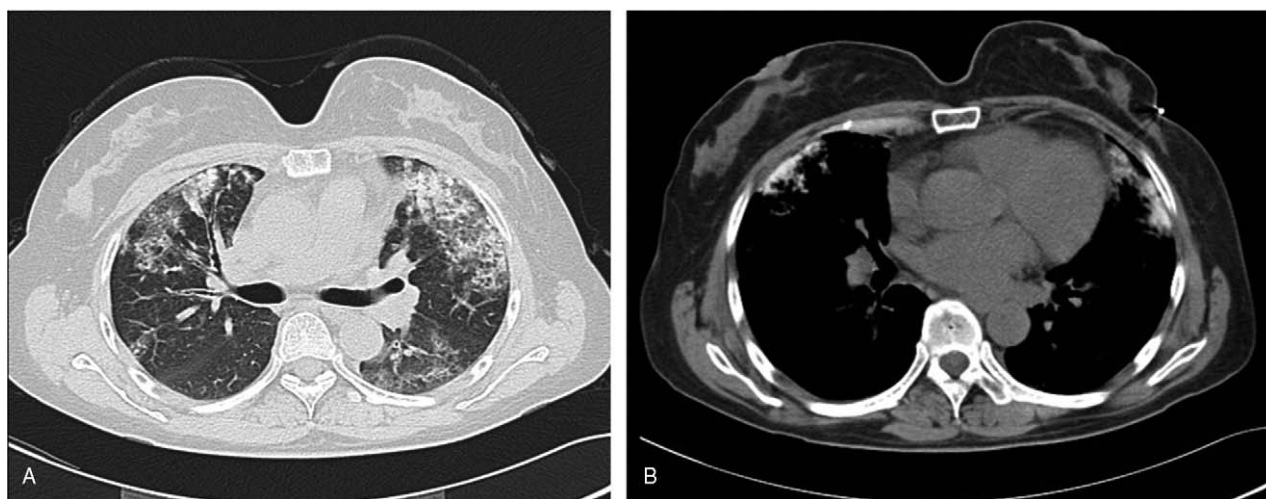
Chest computed tomography performed 15 months after discharge. (A and B) Significantly absorbed patchy shadows.
